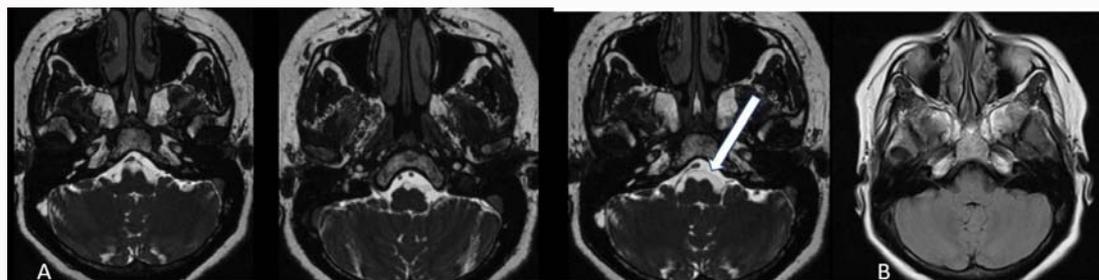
CISS sequence in A shows disappearance of the cystic lesion with thin floating membrane (arrow) and FLAIR in B shows no hyper intensity as was seen in Figure 1.
